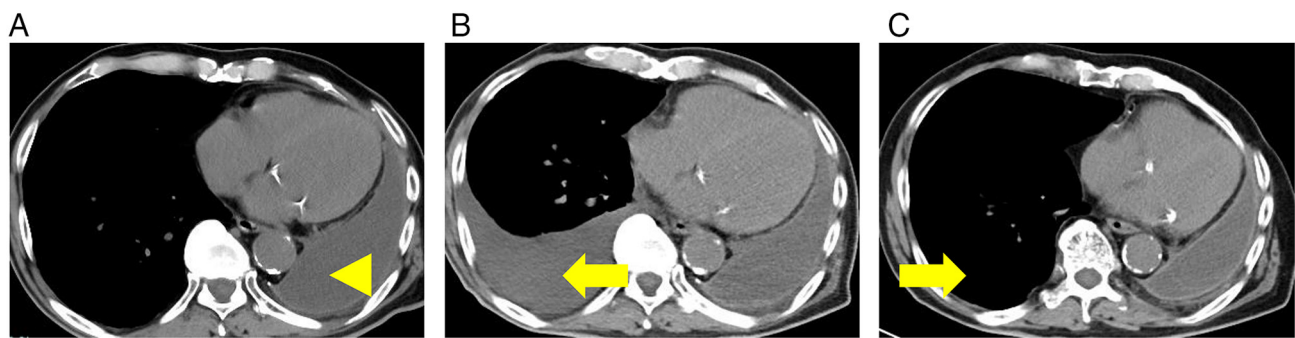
Serial chest CT findings. (A) CT in February 2025. The arrowhead indicates fluid in the left hemithorax, representing filling of the post-pneumectomy space as a postoperative change rather than a pathological effusion; this finding had remained unchanged since the early postoperative period. (B) CT in April 2025 showing a right pleural effusion (arrow). (C) CT in September 2025 showing no reaccumulation of the right pleural effusion (arrow). CT, computed tomography.
